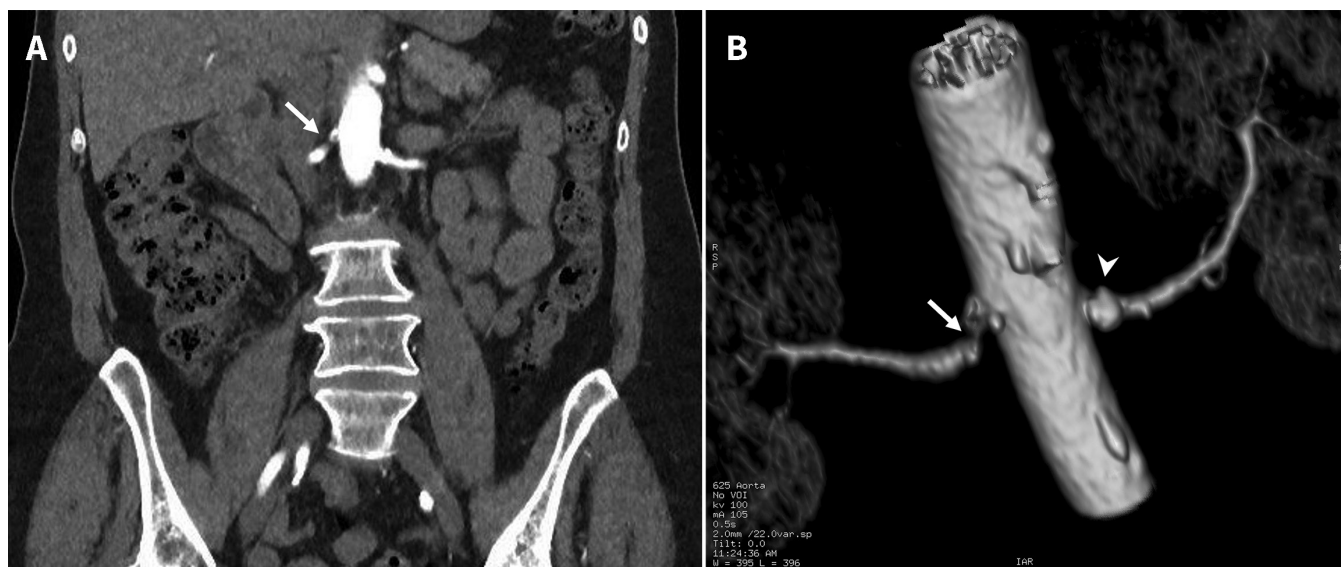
(A) Computed tomographic renal angiogram of a 69-year-old woman showing right renal artery stenosis (estimated occlusion up to 90%) at site of origin (arrows) in the coronal plane and (B) three-dimensional reconstruction. The left renal artery shows heavy ostial calcification (arrow-head) but no stenosis.
